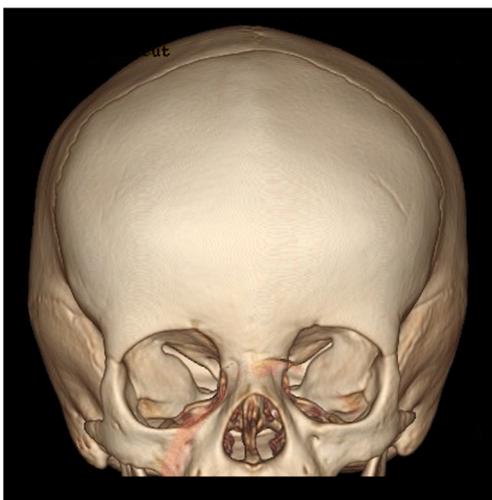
A 3D CT scan of a fused metopic suture in a 21.5-month-old patient. The suture line has completely ossified from glabella to the anterior fontanel
